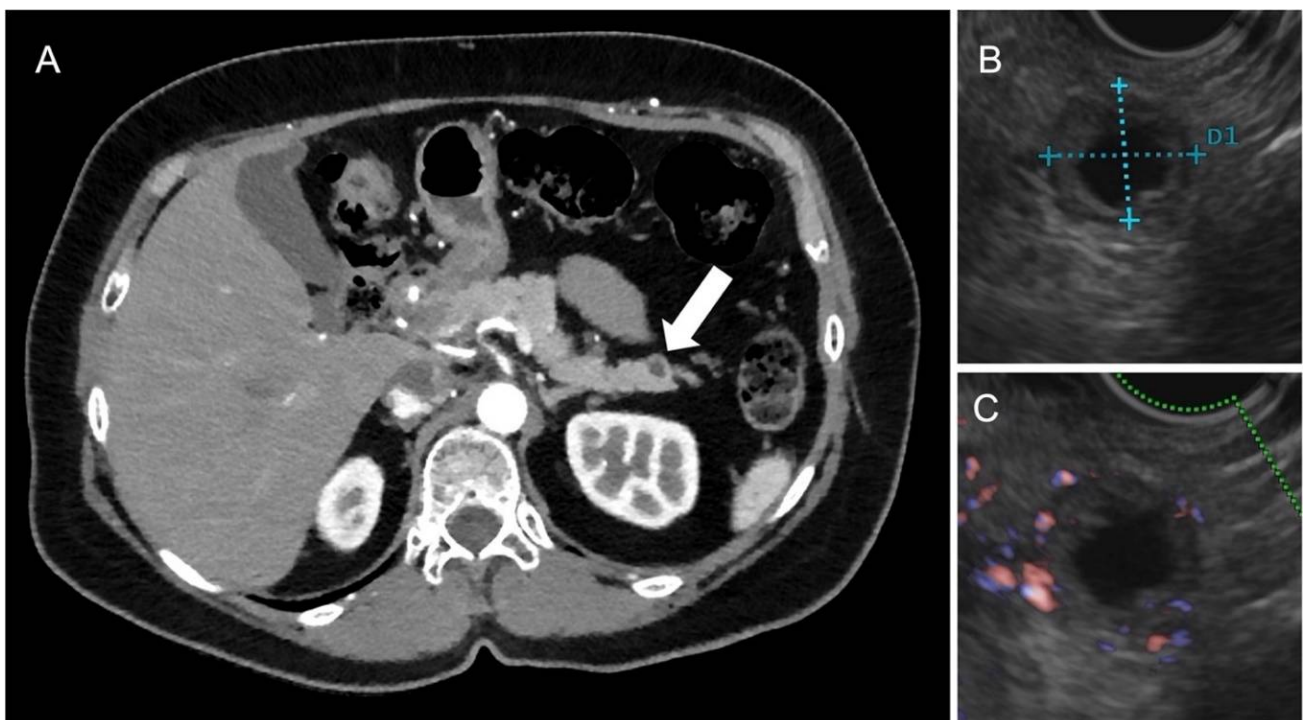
Arterious CT scan (A) demonstrating a hypodense lesion at pancreatic tail (arrow), which, at echoendoscopy, showed anechoic content (B) with hypervascularized thick walls at Doppler, and after a bolus of ultrasound contrast agent (C). The tumor was surgically removed and diagnosed as G1 NEN tumor with cystic appearance.
